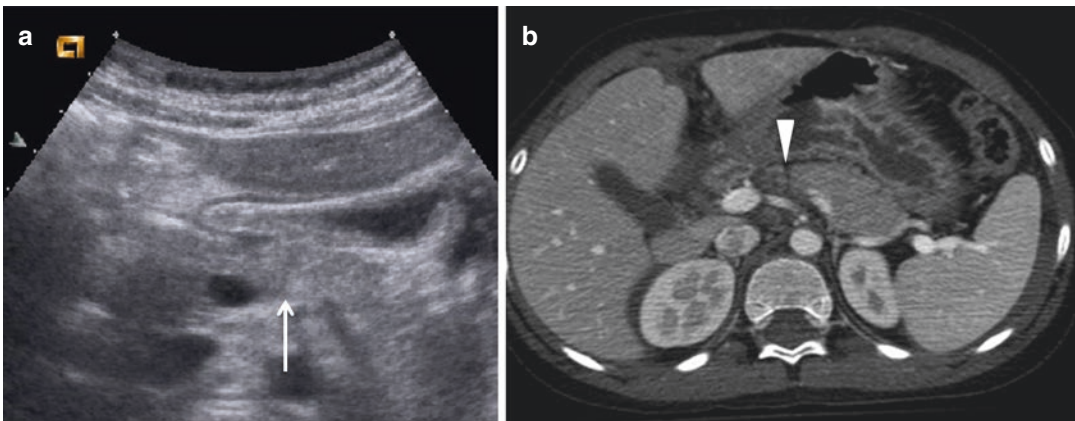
Ultrasonography (a) shows pancreatic body transection, which appears as a thin hypodense linear image through the pancreatic body (arrow). Contrast-enhanced CT (b) confirms the pancreatic lesion (arrowhead)
